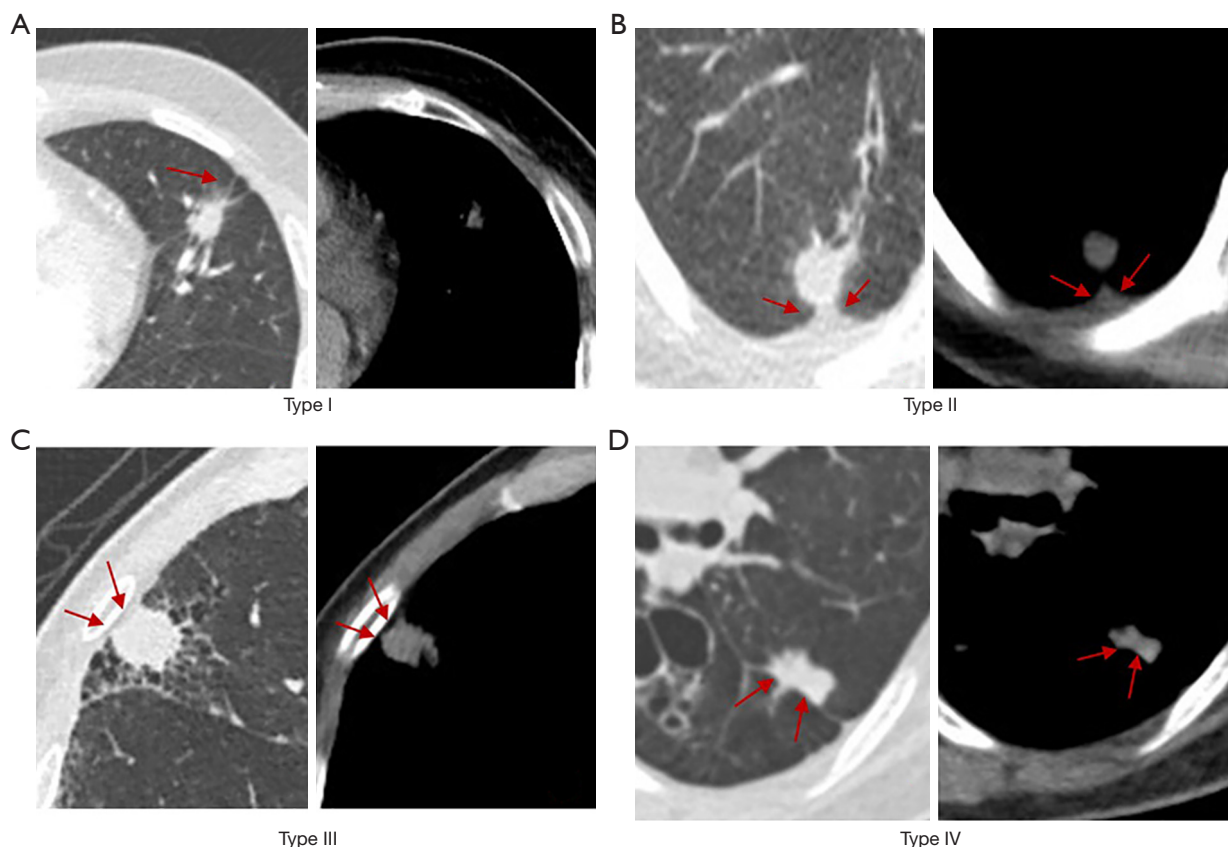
Representative CT images of pleural tag in SILADC. SILADC with pleural tag of type I (A), type II (B), type III (C), and type IV (D) (red arrows) on lung and mediastinal window images. CT, computed tomography; SILADC, small-sized invasive lung adenocarcinoma.
